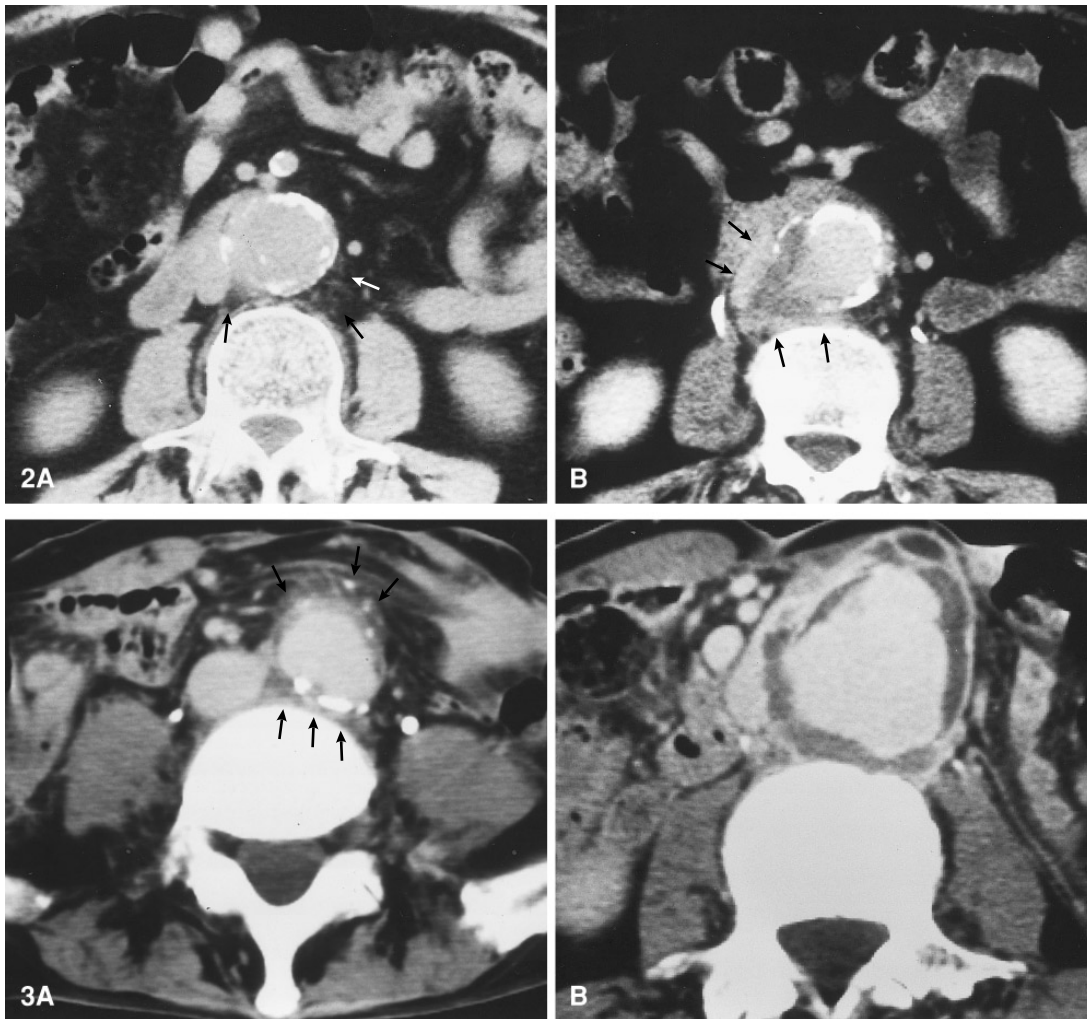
A The initial CT shows a slight increase of fat density adjacent to the posterior infrarenal aortic wall (arrows). B Contrast-enhanced CT demonstrates an enlargement of the aorta with an enhancement of a small periaortic mass (arrows).
